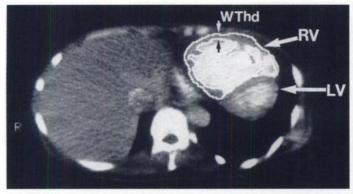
Photograph showing typical short-axis computed tomogram at midventricular level in patient with primary pulmonary hypertension. Endocardial and epicardial border lines of right ventricular cavity are drawn to calculate right ventricular ejection fraction, volume and myocardial mass at corresponding level. Wall thickness in lateral regions of right ventricle (RV) was also measured at end-diastole (WThd) and end-systole. LV = left ventricle.
